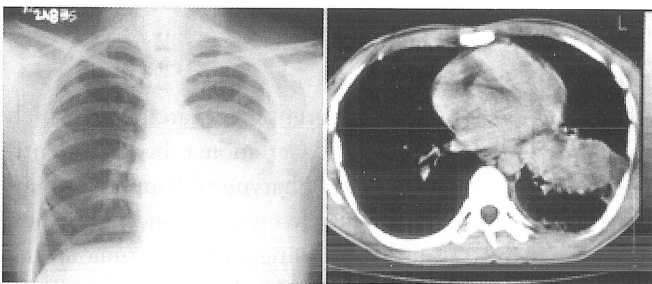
Chest radiography and computed tomography at the admission.
